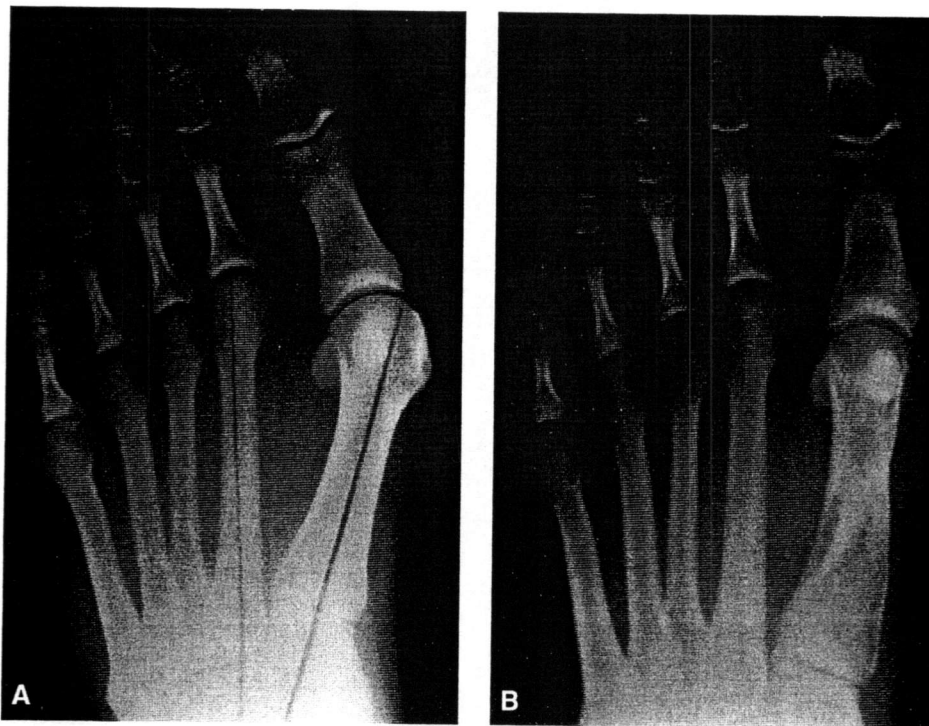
Preoperative (A) postoperative (B) radiographs of a patient after a healed Mau osteotomy and after removal of fixation.
